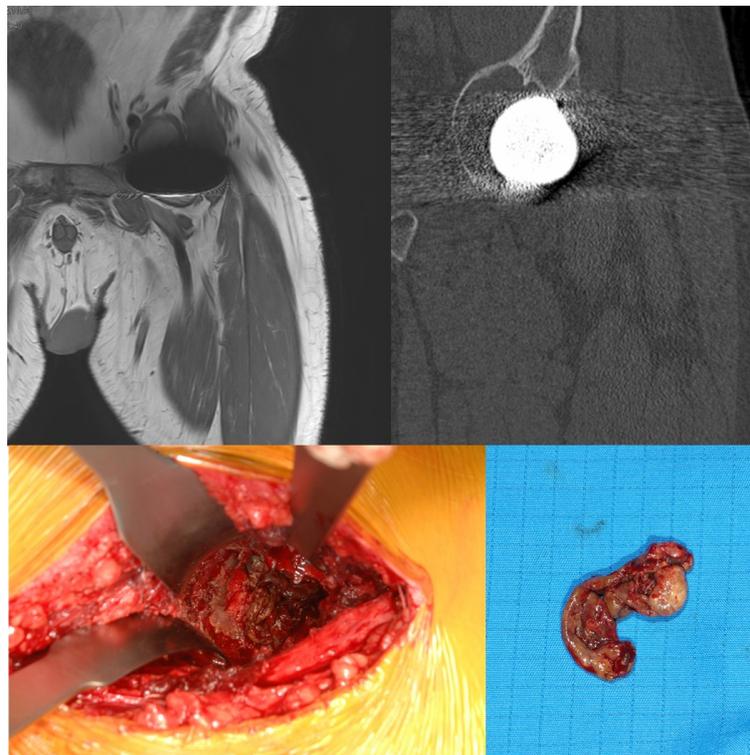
MRI and CT scan of an ASR™XL Head device showing an ARMD and a supraacetabular osteolysis as well as photographs of the resected ARMD intraoperatively.
